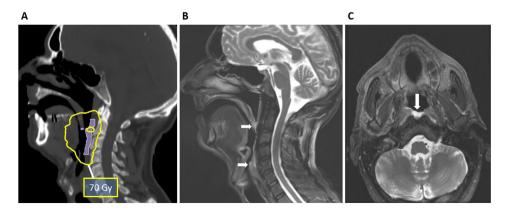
Sagittal view of radiotherapy planning computerized tomography (A) depicting the original gross tumor volume (colour wash) and 70 Gy isodose line encompassing the anterior components of C2–C3 vertebral bodies where osteomyelitis occurred. Sagittal (B) and axial (C) fat-saturated T2-weighted magnetic resonance images show evolving tumor ulceration along the posterior oropharyngeal wall (arrows).
